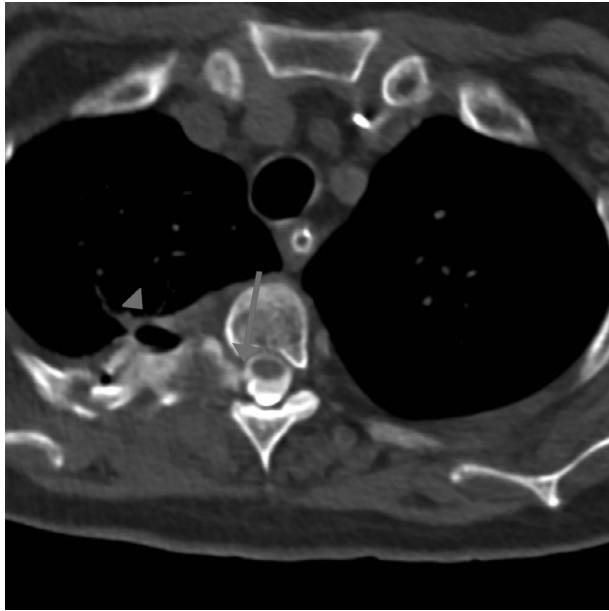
Thoracic spine CT myelogram: at the level of T3-T4, there is contrast extravasation noted tracking from the spinal canal through a fistulous tract (arrow) along the right neural foramina into the right pleural cavity (arrowhead) likely secondary to a dural tear.
